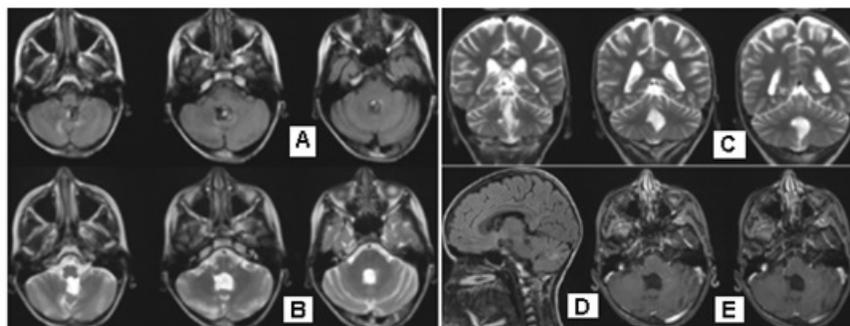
Brain MRT/ July 2019- A residual lesion measuring 4.5 mm without perifocal edema A/ Ax T2 FLAIR; B/ Ax T2 fr FSE; C/ COR T2 fr FSE; D/ Sag T2 FLAIR; E/Ax T1 FSPGR.
